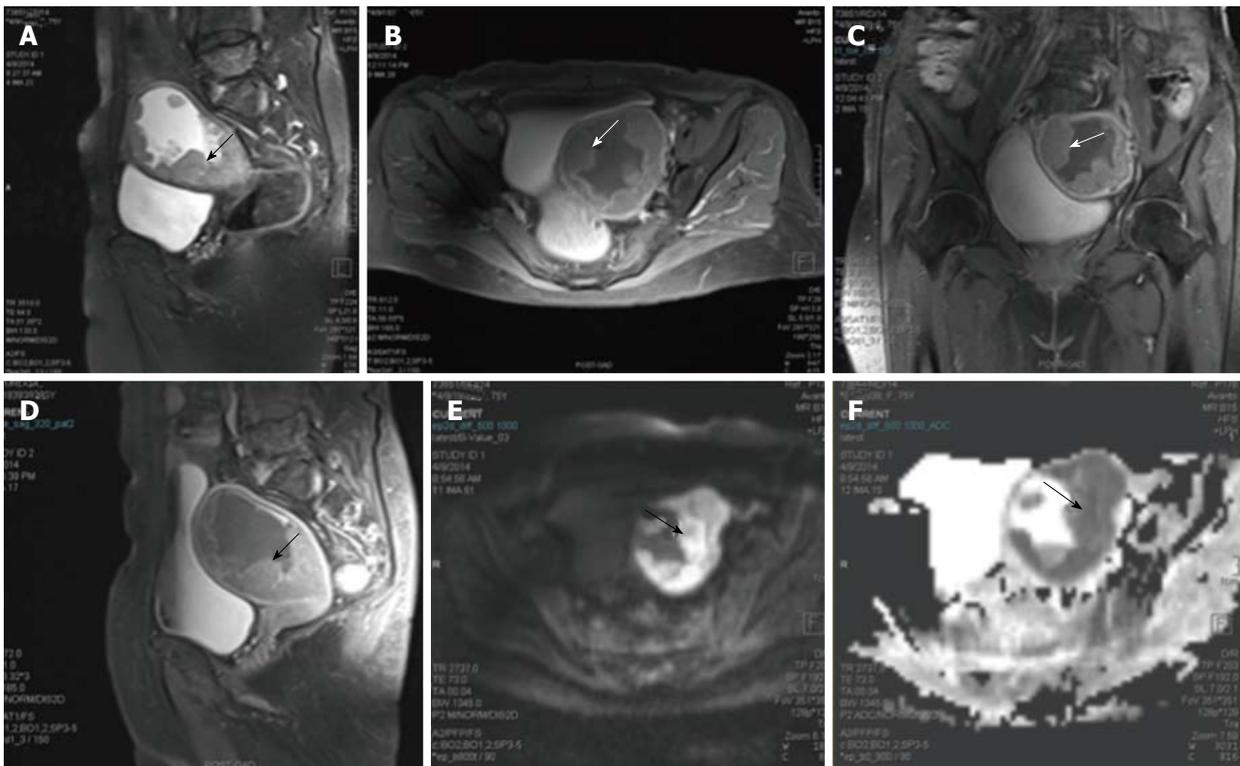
Endometrial carcinoma. Sagittal T2 weighted magnetic resonance image of a female who presented with menorrhagia. It shows irregular nodular thickening of the endometrial (arrow in A). The lesion on post contrast axial (B), coronal (C) and sagittal (D) images shows enhancement. On diffusion weighted imaging (E) and corresponding apparent diffusion coefficient (F) images, the lesion showed significant restriction of diffusion. The tumour is limited to the outer myometrium and no parametrial invasion noted suggesting a T1c disease. This lesion on biopsy turned out to be carcinoma endometrium.
